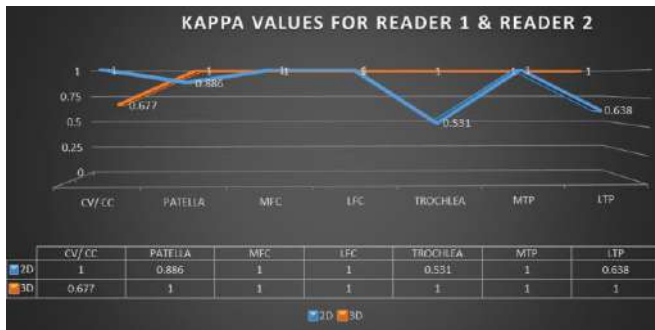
Comparison between 2D & 3D MRI kappa values of reader 1 and 2
